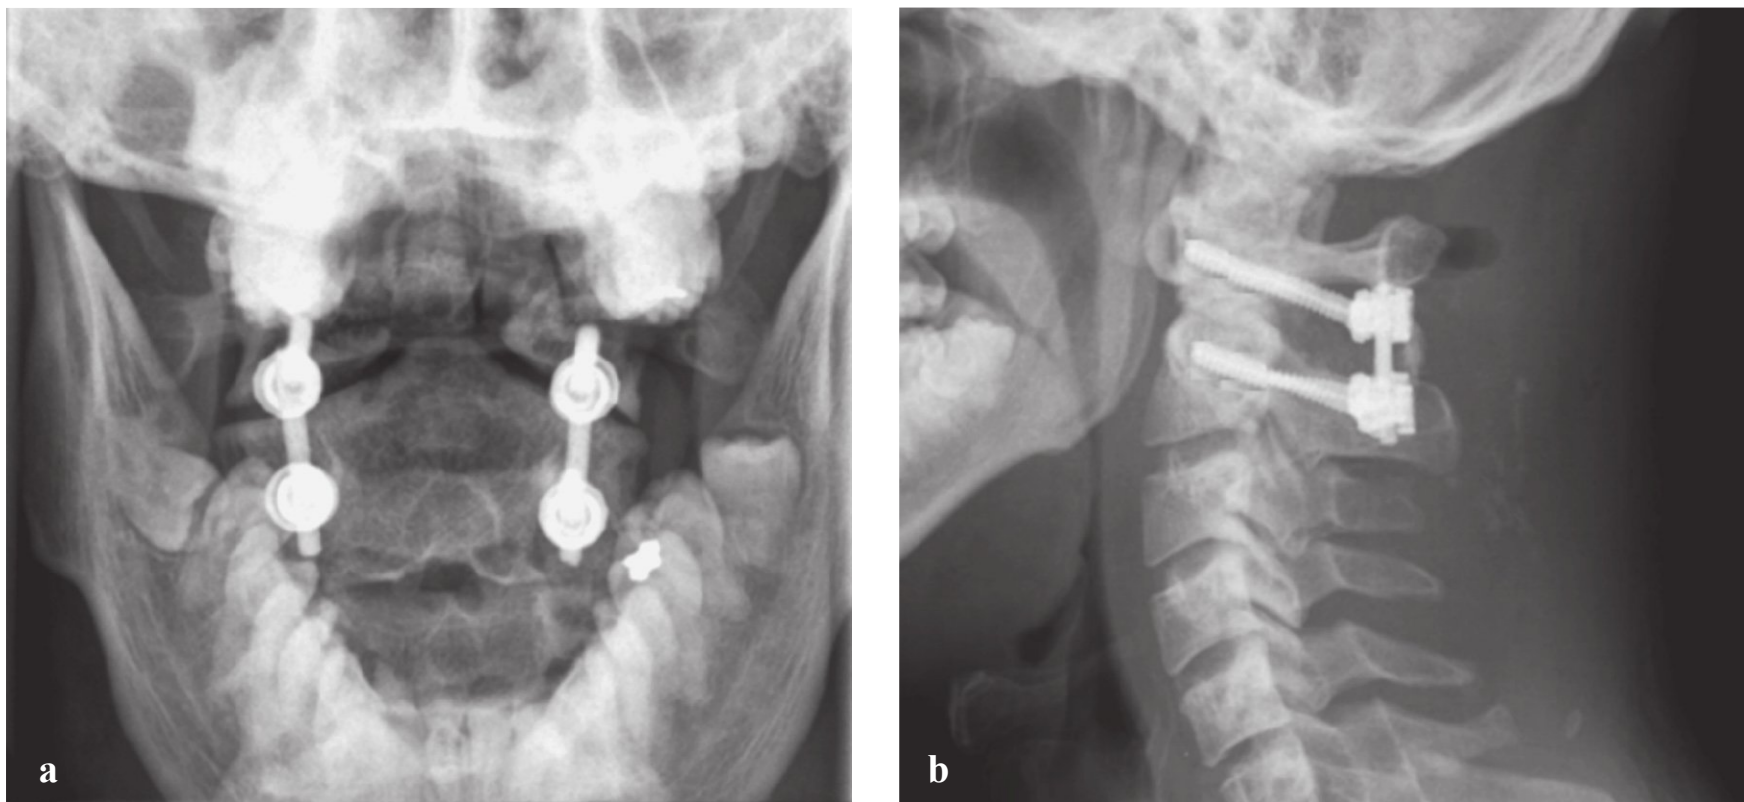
(a) Anteroposterior and (b) lateral radiographs demonstrating a C1–C2 posterior cervical fusion accomplished via a C1 lateral mass screw and C2 pedicle screw.
